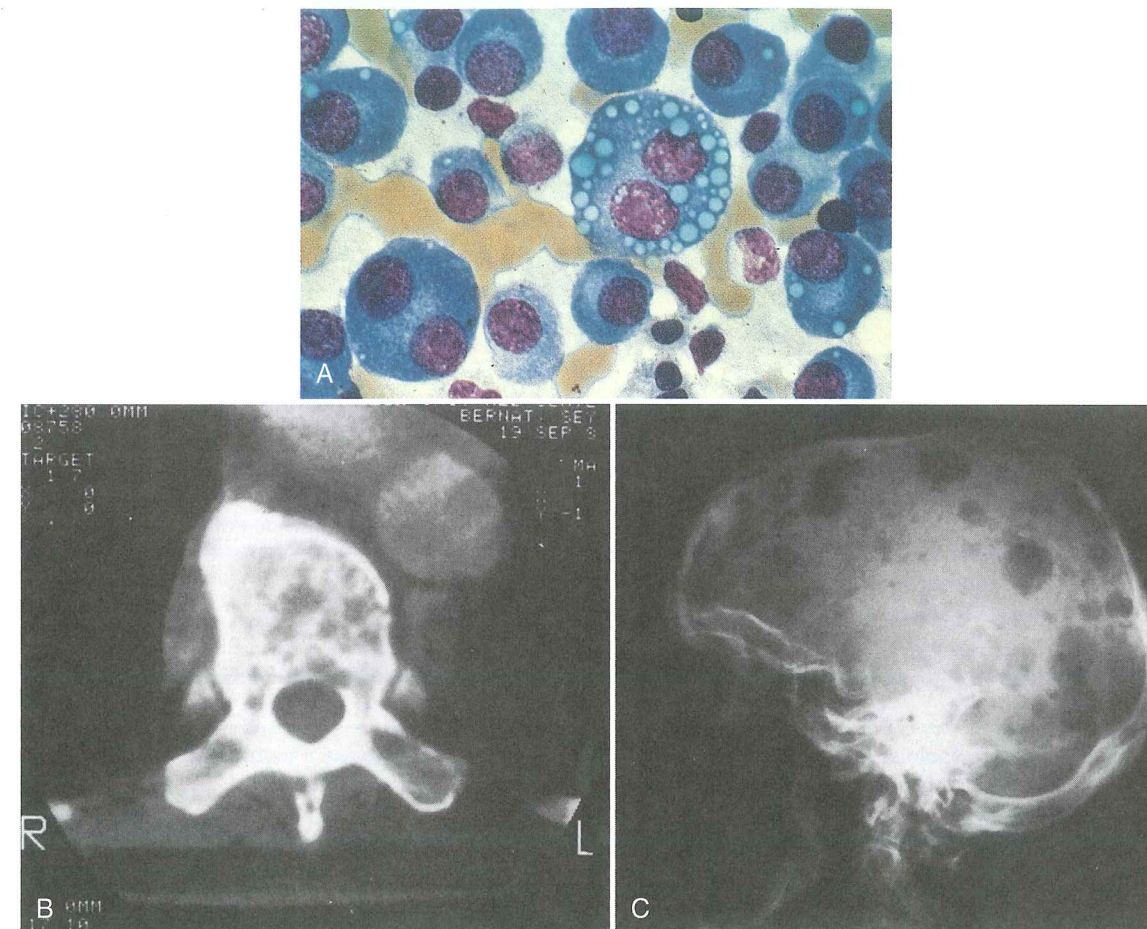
A, Bone marrow aspirate from a patient with multiple myeloma showing a large number of abnormal plasma cells with multiple nuclei and cytoplasmic droplets. (From Kumar V, et al, editors: Robbins Basic Pathology, ed 8, Philadelphia, 2007, Saunders, p 455.) Vertebral body (B) and skull (C) radiographs showing the characteristic "honeycomb" appearance of demineralized bone associated with multiple myeloma. (Courtesy Marvin J. Stone, MD, Sammons Cancer Center, Baylor University Medical Center, Dallas. From Copstead LE, Banasik J: Pathophysiology, ed 5, St. Louis, 2013, Mosby.)
